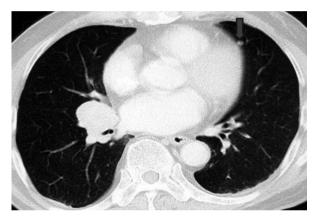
Chest CT revealed a nodule at the left lower lung (arrow)
